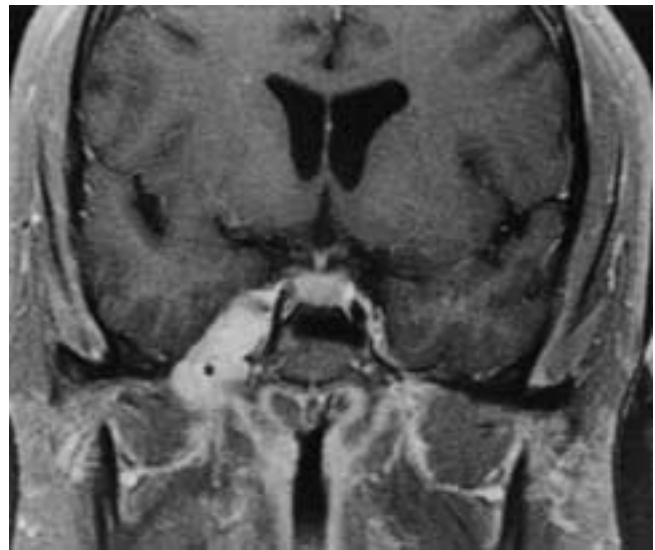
Right cavernous sinus/Meckel's cave schwannoma with extension through the foramen ovale. Coronal contrast-enhanced, fat-suppressed T1-weighted MR image shows an enhancing mass extending inferiorly through a grossly widened foramen ovale (*asterisk*). For [Figures 13-26](#) and [13-27](#), prior to establishing the diagnosis, the possibility of PNS from a head and neck cancer should at least be considered and sought radiographically. (From Ginsberg LE. Imaging of perineural tumor spread in head and neck cancer. *Semin Ultrasound CT MR* 1999;2:175–186.)
